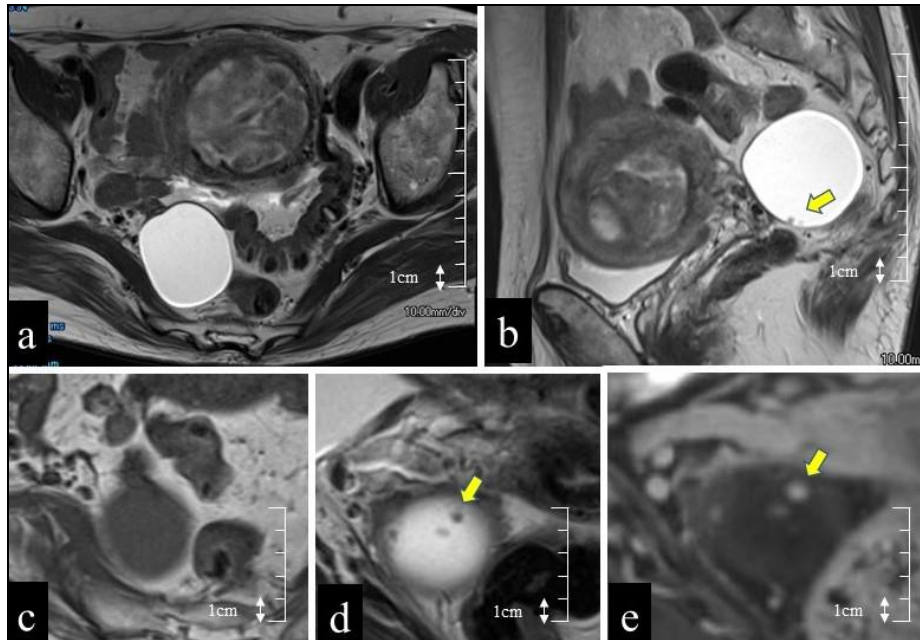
Magnetic resonance imaging of the pelvic tumor. The tumor had low-signal intensity on T1-weighted images and high-signal intensity on T2-weighted images, while the nodules had low-signal intensity on T1- and T2-weighted images and had contrast enhancement. The yellow arrows show the nodules. (a), (b), (d) are the T2 weighted images, (c) is the T1-weighted image, and (e) is the contrast-enhanced T1-weighted image.
